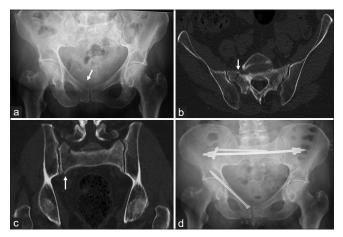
(a) A 79-year-old female suffers a ramus superior and inferior fracture at the right side after a fall at home (arrow). There is no clear fracture of the posterior pelvis in the pelvic AP radiograph. (b) Axial computed tomography (CT)-cuts through the sacrum reveal a complete fracture on the right (arrow) and a crush zone on the left. (c) Coronal CT reconstruction reveals a complete fracture of the right lateral mass of the sacrum (arrow). There also is an irregularity of the anterior cortex of the left sacral ala. (d) After unsuccessful conservative treatment, a posterior and anterior minimal-invasive stabilization is carried out. A trans-sacral bar and right ilio-sacral screw and a retrograde transpubic screw on the right side are inserted.
